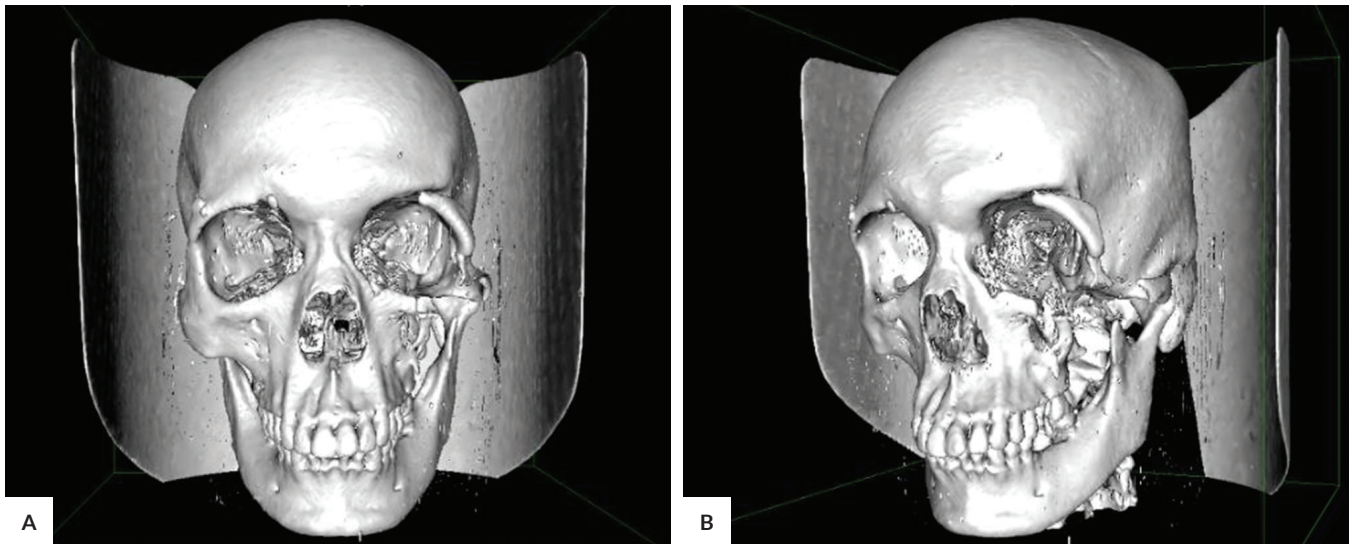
3D-reconstruction of craniofacial CT scan viewed in Horos v3.3.6. (A) Front-view, (B) Left 45-degree view.
